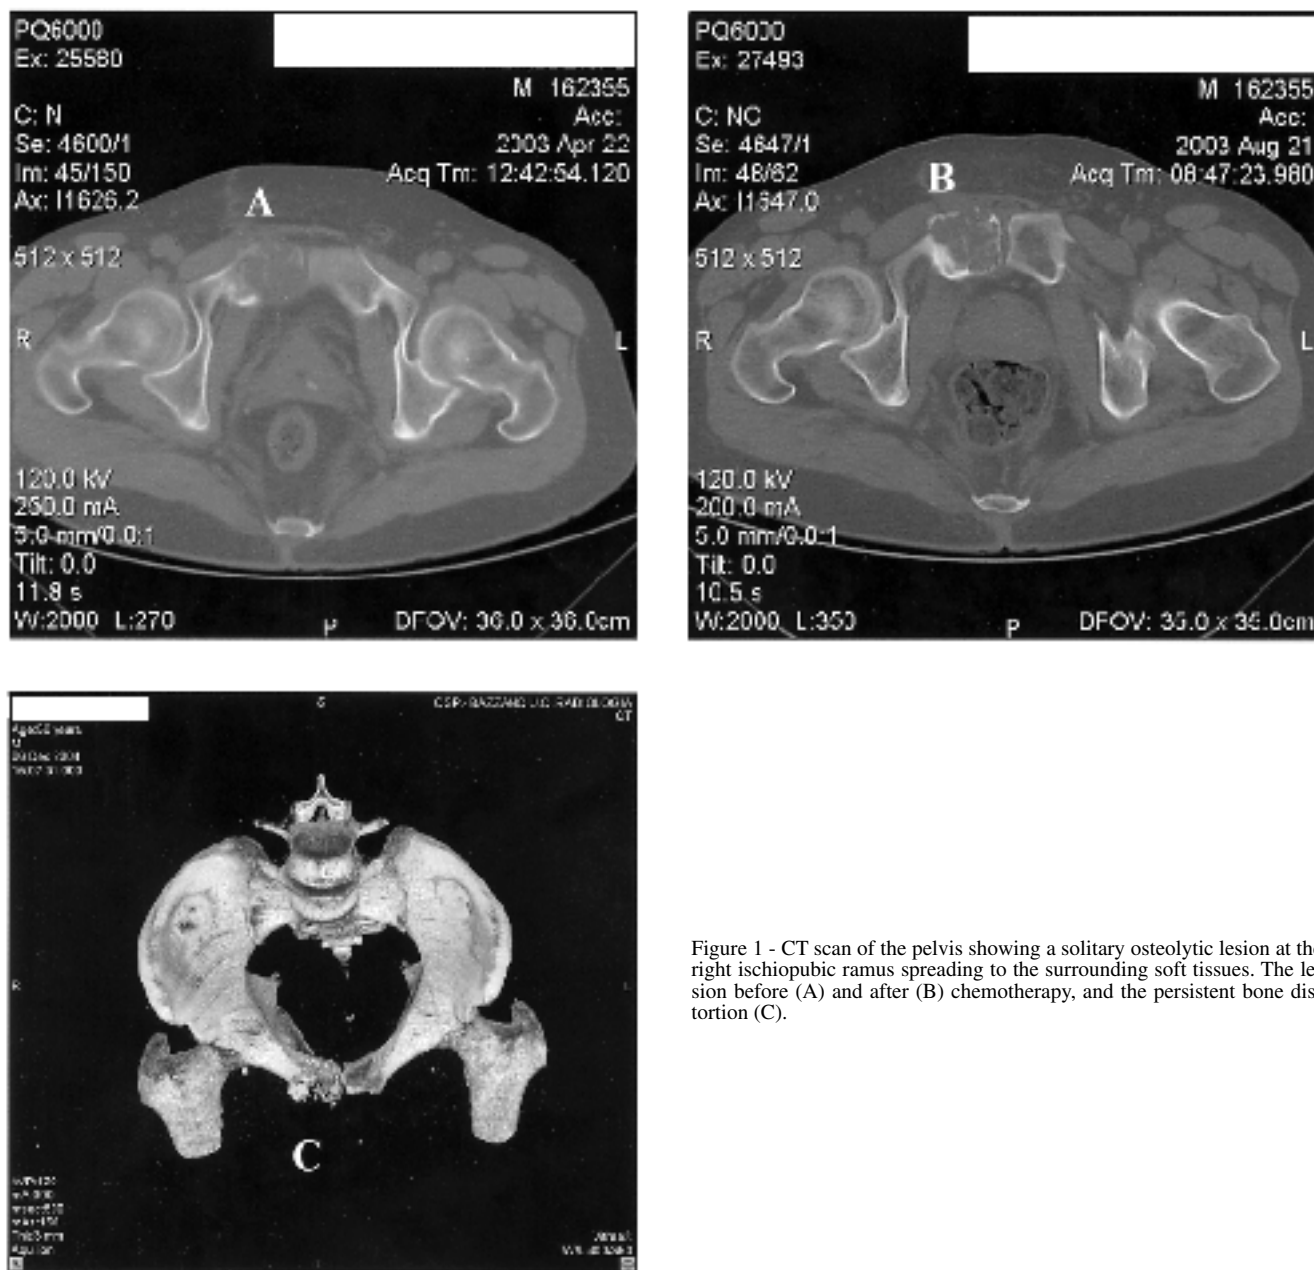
CT scan of the pelvis showing a solitary osteolytic lesion at the right ischiopubic ramus spreading to the surrounding soft tissues. The lesion before (A) and after (B) chemotherapy, and the persistent bone distortion (C).
